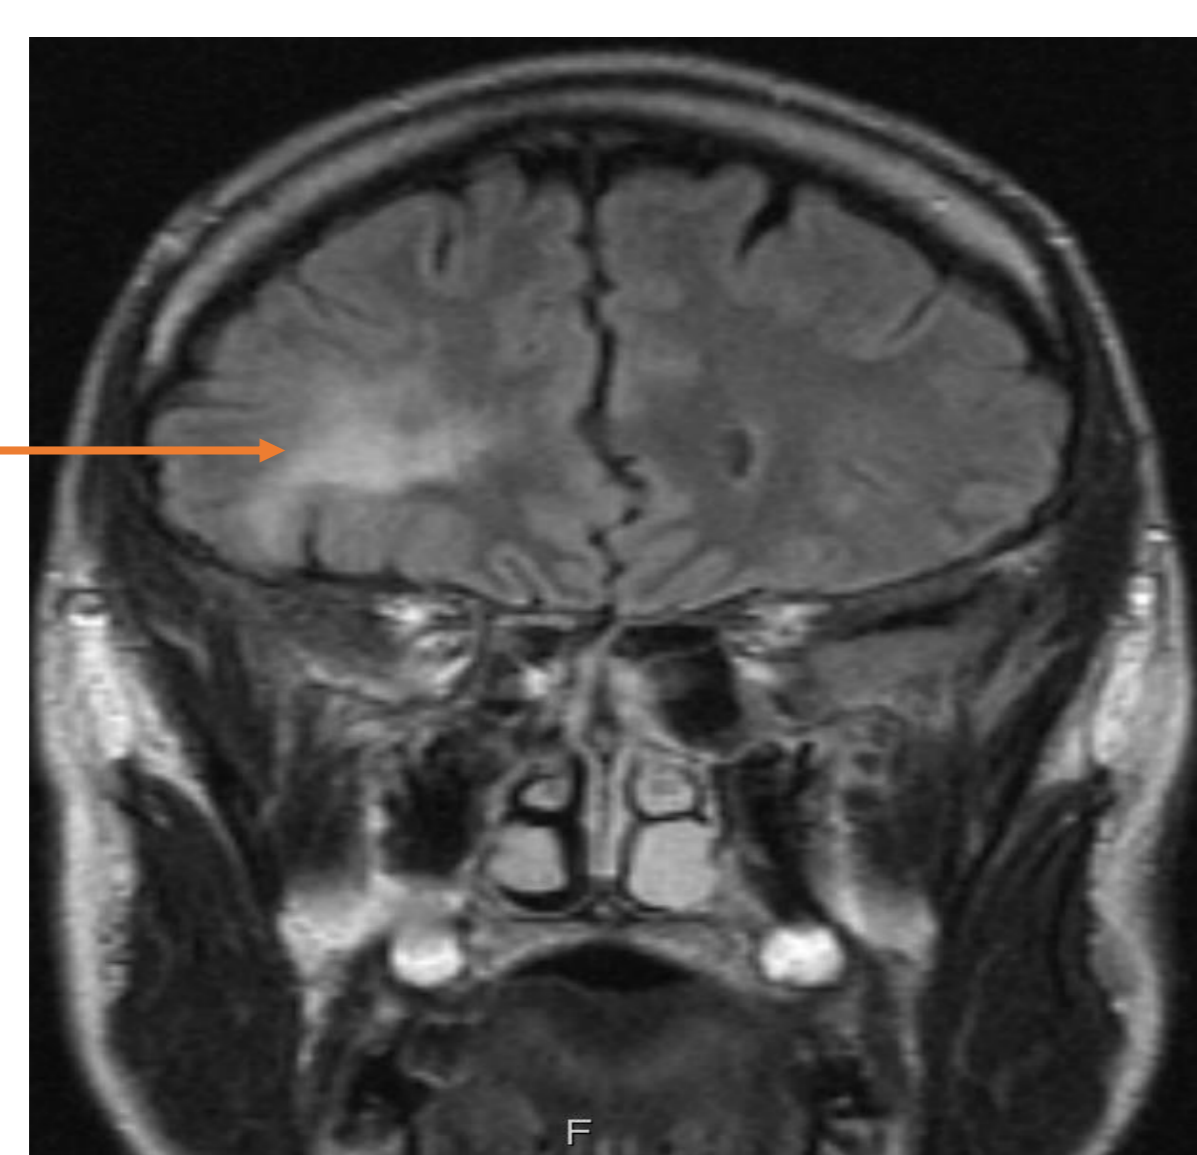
Coronal MRI portraying the glioma in the right hemisphere.
